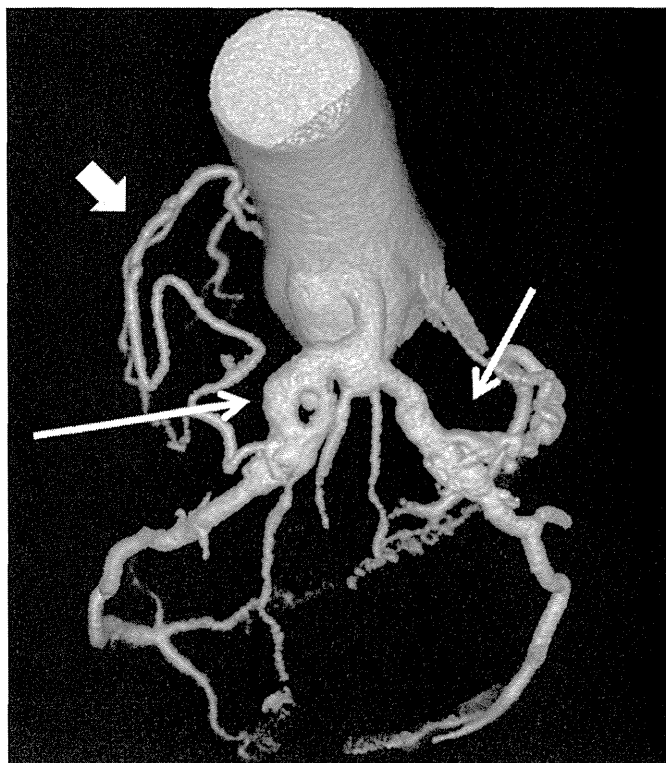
A multi-detector X-ray computed tomography revealed persistent giant coronary artery aneurysm (CAA) with 12 mm in diameter at segment 6 (white thin arrow), stenosis distal to this CAA, persistent giant CAA with 12 mm in diameter at segment 11 (white thin arrow), and total occlusion of right coronary artery with collaterals from left coronary artery (white thick arrow).
